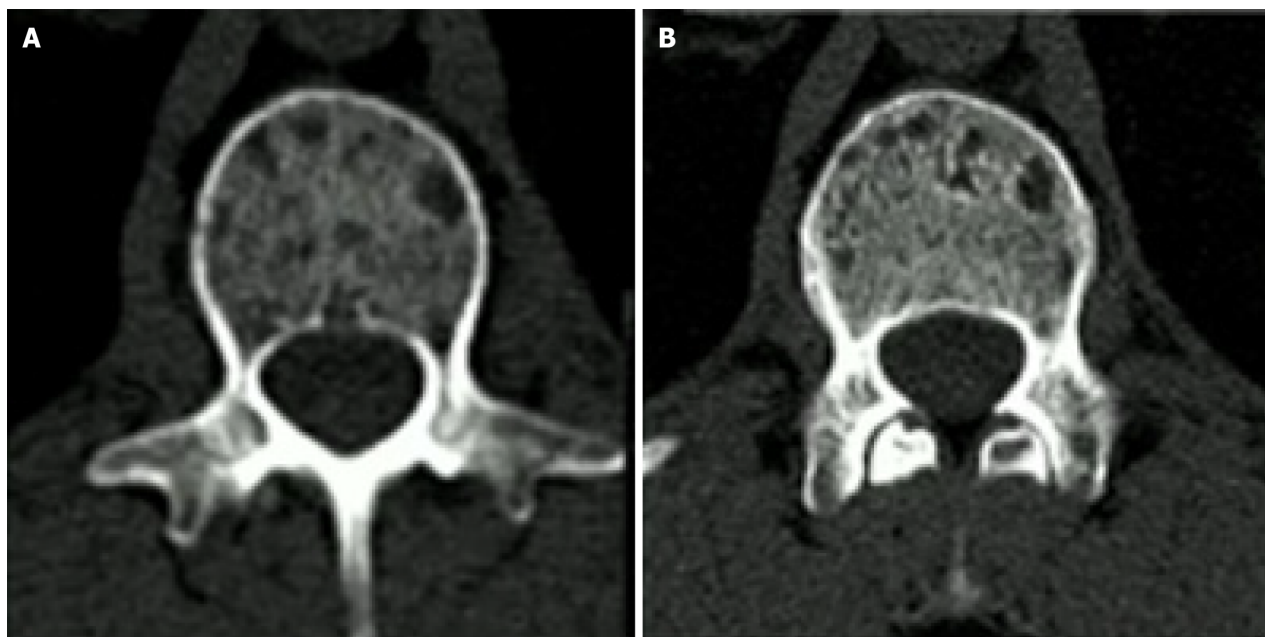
Comparison between second generation dual energy CT and photon-counting detector CT. The images were obtained from the vertebra of a 56-year-old patient with multiple myeloma[19]. Note the improvement in spatial resolution in the photon-counting detector CT image with a better depiction of trabeculae and osteolysis. A: Second generation dual energy CT; B: Photon-counting detector CT. Citation: Siemens Healthineers. The NAEOTOM Alpha class. Available from: <https://www.siemens-healthineers.com/computed-tomography/naeotom>. Copyright ©Siemens Healthineers AG 2024. The authors have obtained the permission (Supplementary material).
